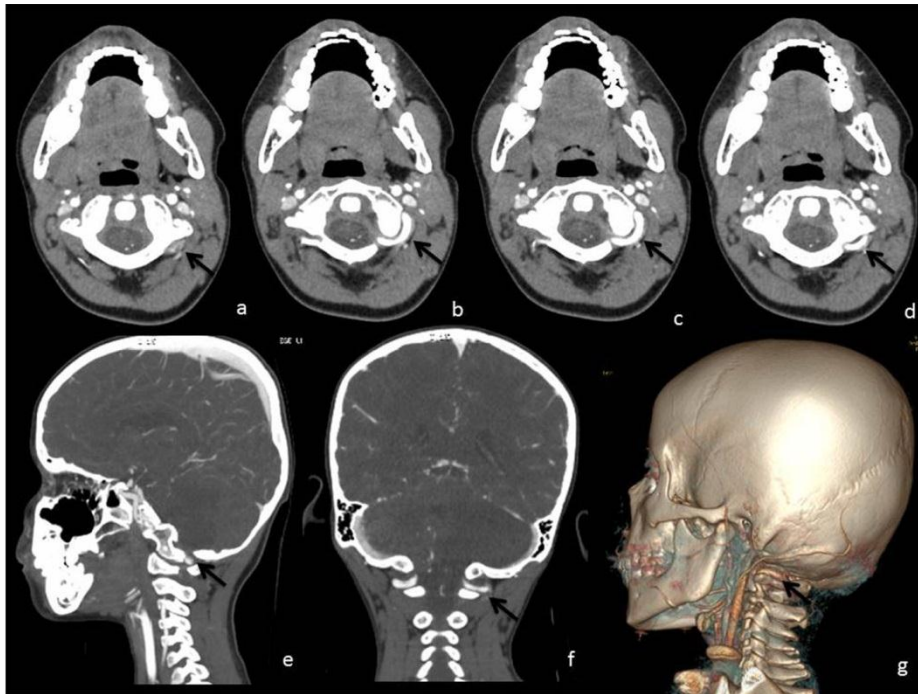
Axial CT angiography images (a, b, c, d), sagittal (e) and coronal (f) reformatted CT angiography images and volume rendering image. Arrows demonstrate the dissected left vertebral artery V3-V4 segments.
